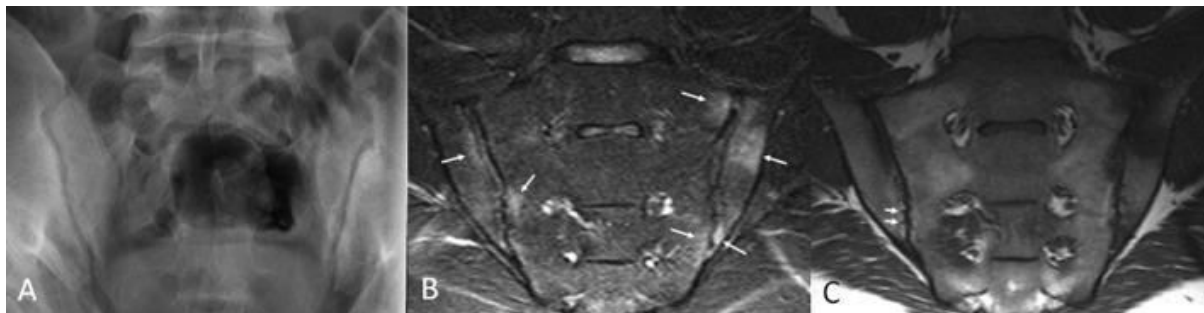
Early sacroiliitis on conventional radiography and MRI. Radiograph (A) of the sacroiliac joints reveals only subtle findings of possible erosion and minimal sclerosis. Short tau inversion recovery (STIR) MRI image (B) performed at the same time shows multiple bone marrow lesions, which appear as oedema (bright; arrows) involving the sacrum and ilium bilaterally, i.e. definite sacroiliitis was documented by MRI.
